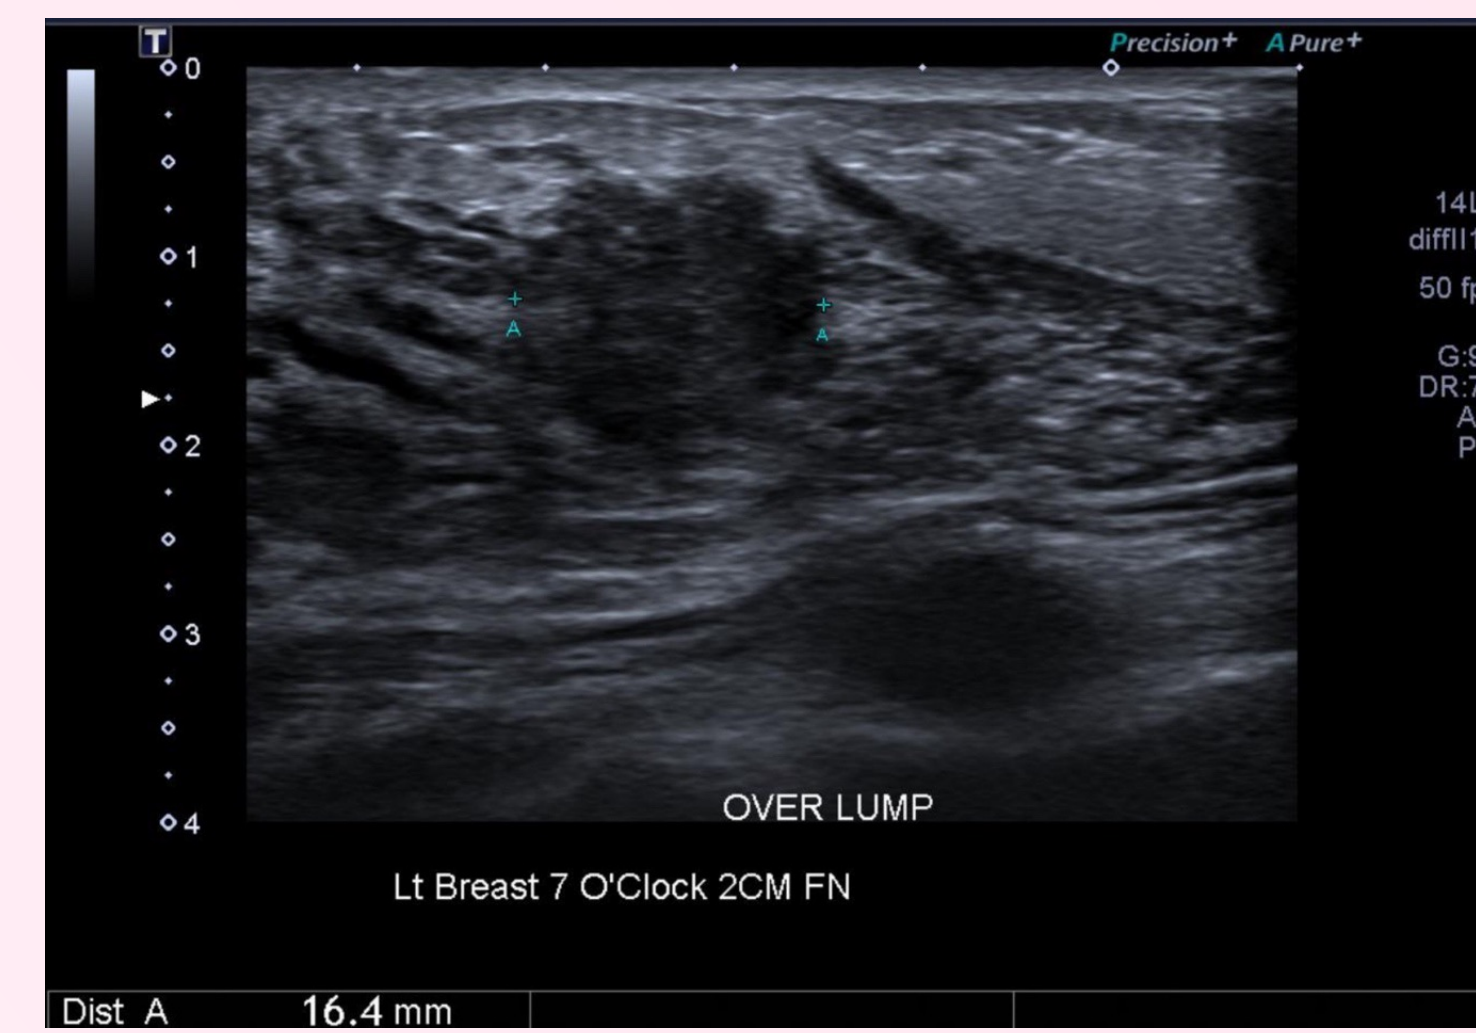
Initial ultrasound of the left breast showing a heterogeneously hypoechoic, ill-defined mass with suggestion of angular margins, measuring 16 x 19 x 15mm, taller than wide and probable internal calcifications.
